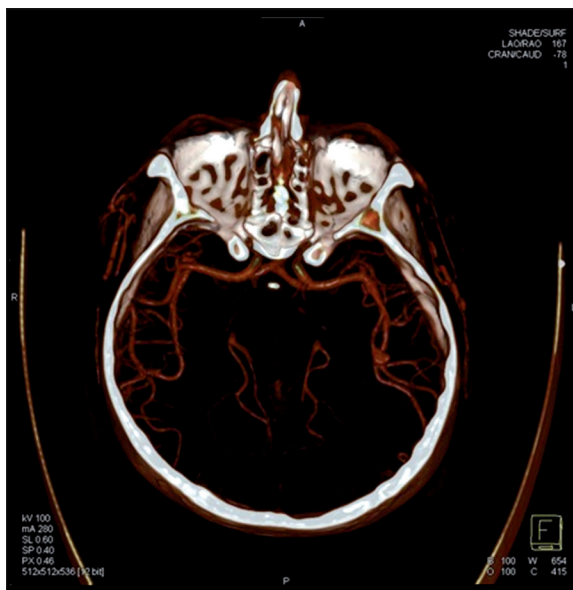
Middle cerebral artery aneurysm in angio-CT.
